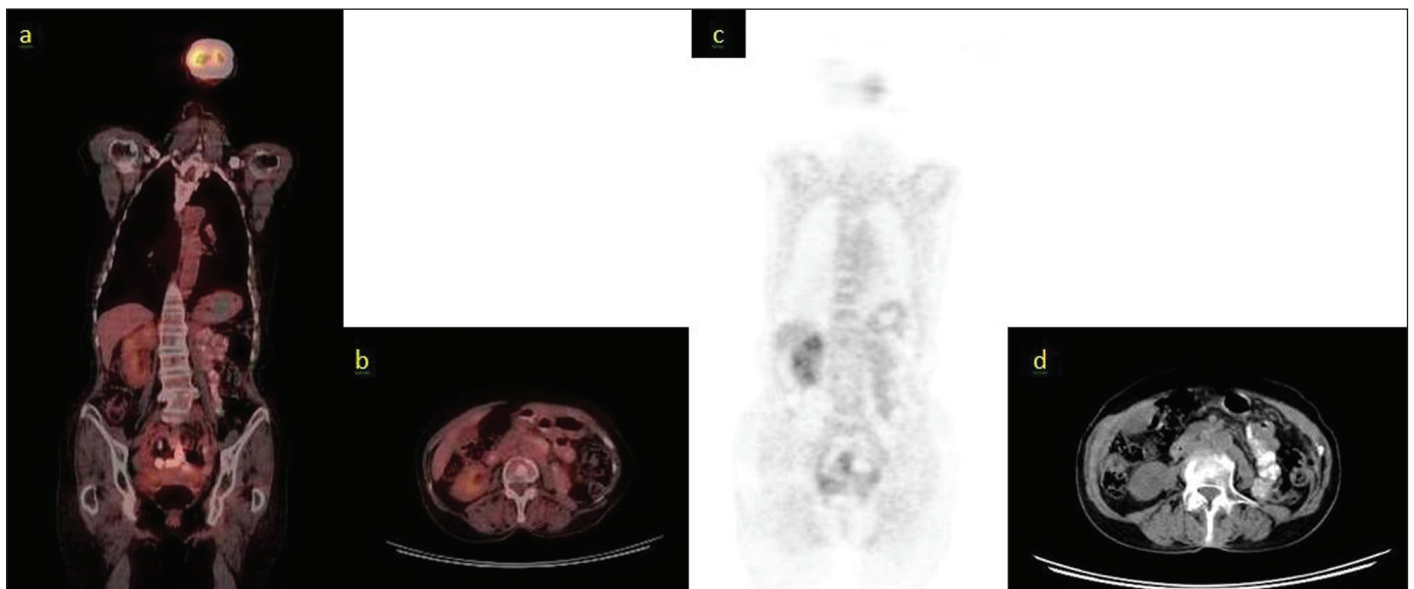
Normal positron-emission tomography/computed tomography of the patient with complete remission following second-line chemotherapy.
